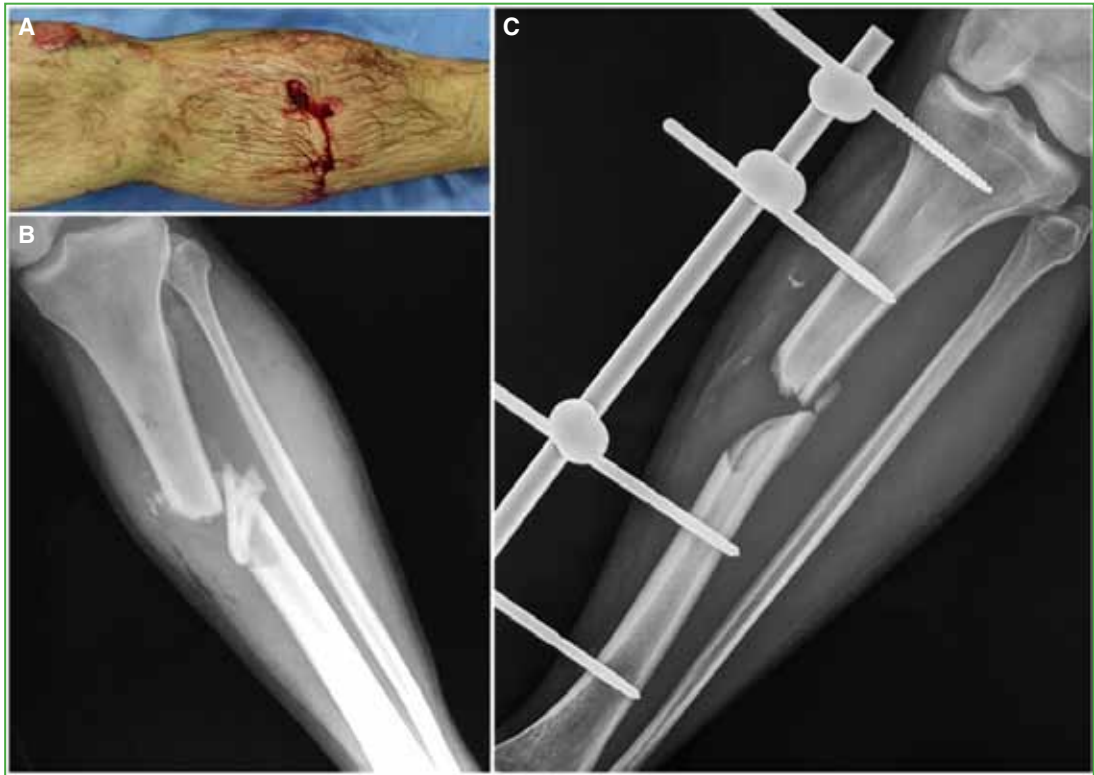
A. Gustilo 2 open fracture, soft tissue injury. B. Anteroposterior radiograph of the leg. The fracture line with segmental bone loss at the distal diaphyseal level of the left tibia is observed. C. Anteroposterior radiograph of the left leg after the first debridement and external fixation.
